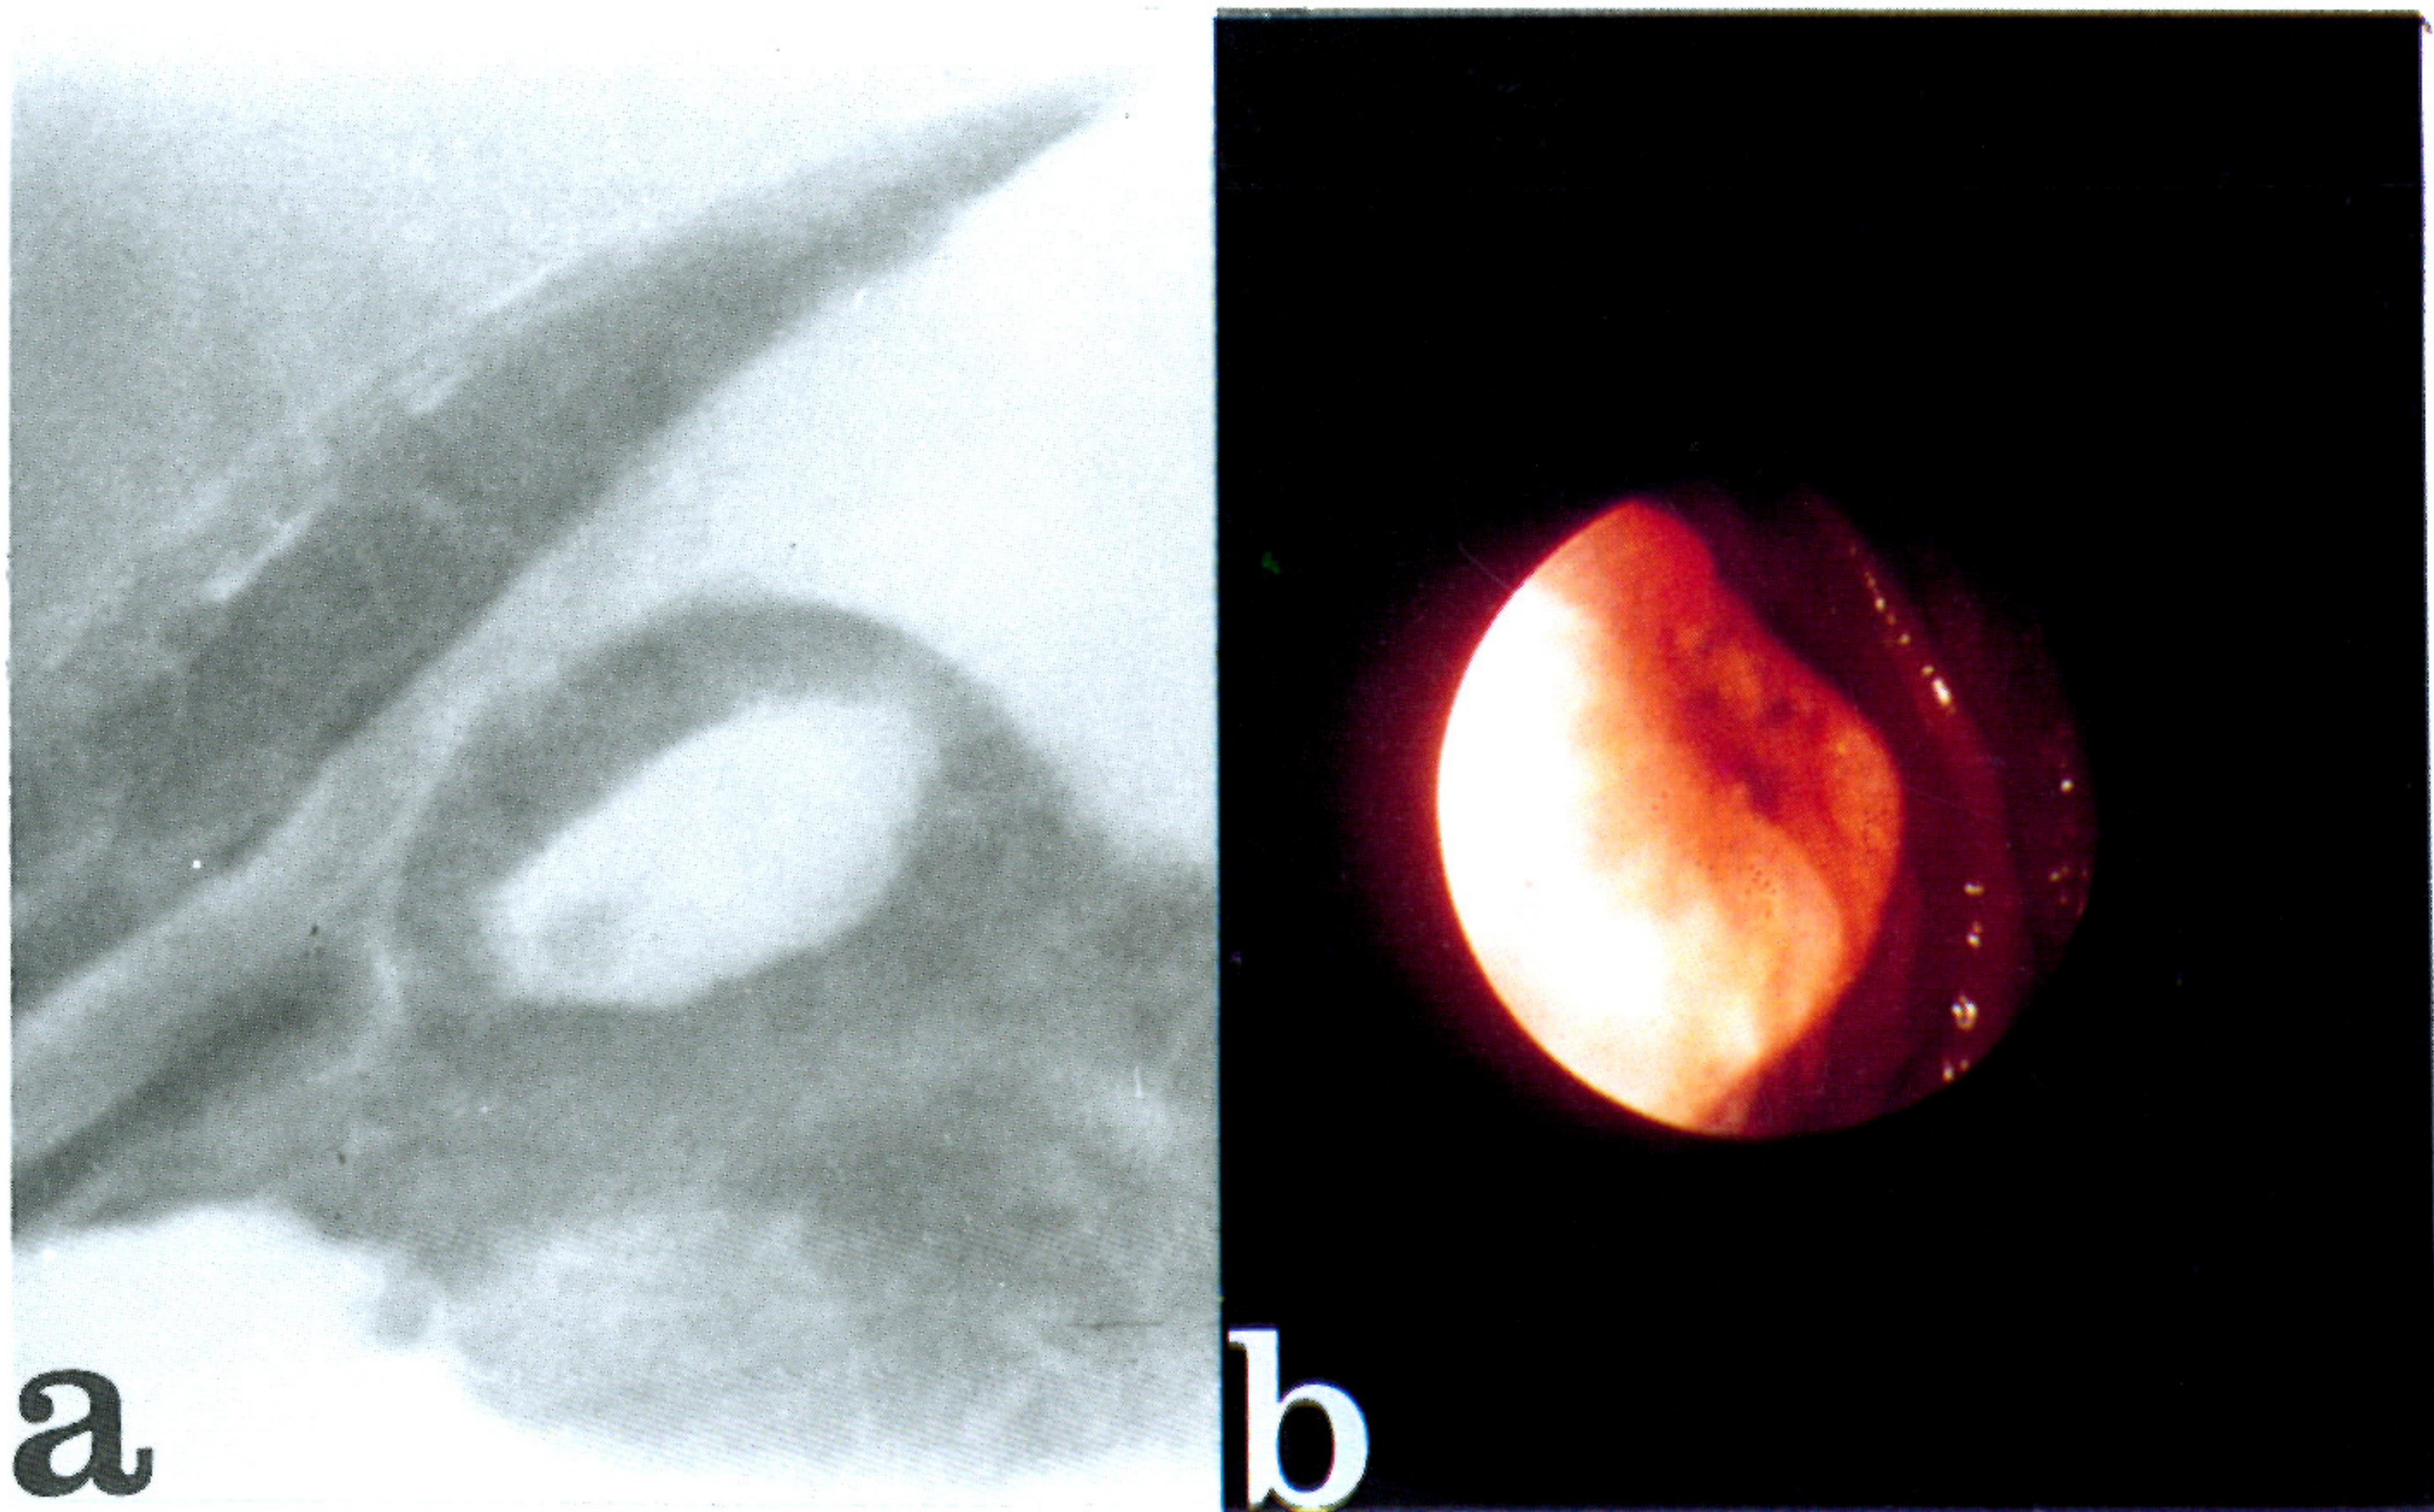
The upper gastrointestinal radiography reveals a mass with central collection of barium resembling the "target" or "bull's eye" lesion (1a). Fiberopticgastroscopy shows a submucosal lesion with central umbilication in the proximal stomach (1b).
